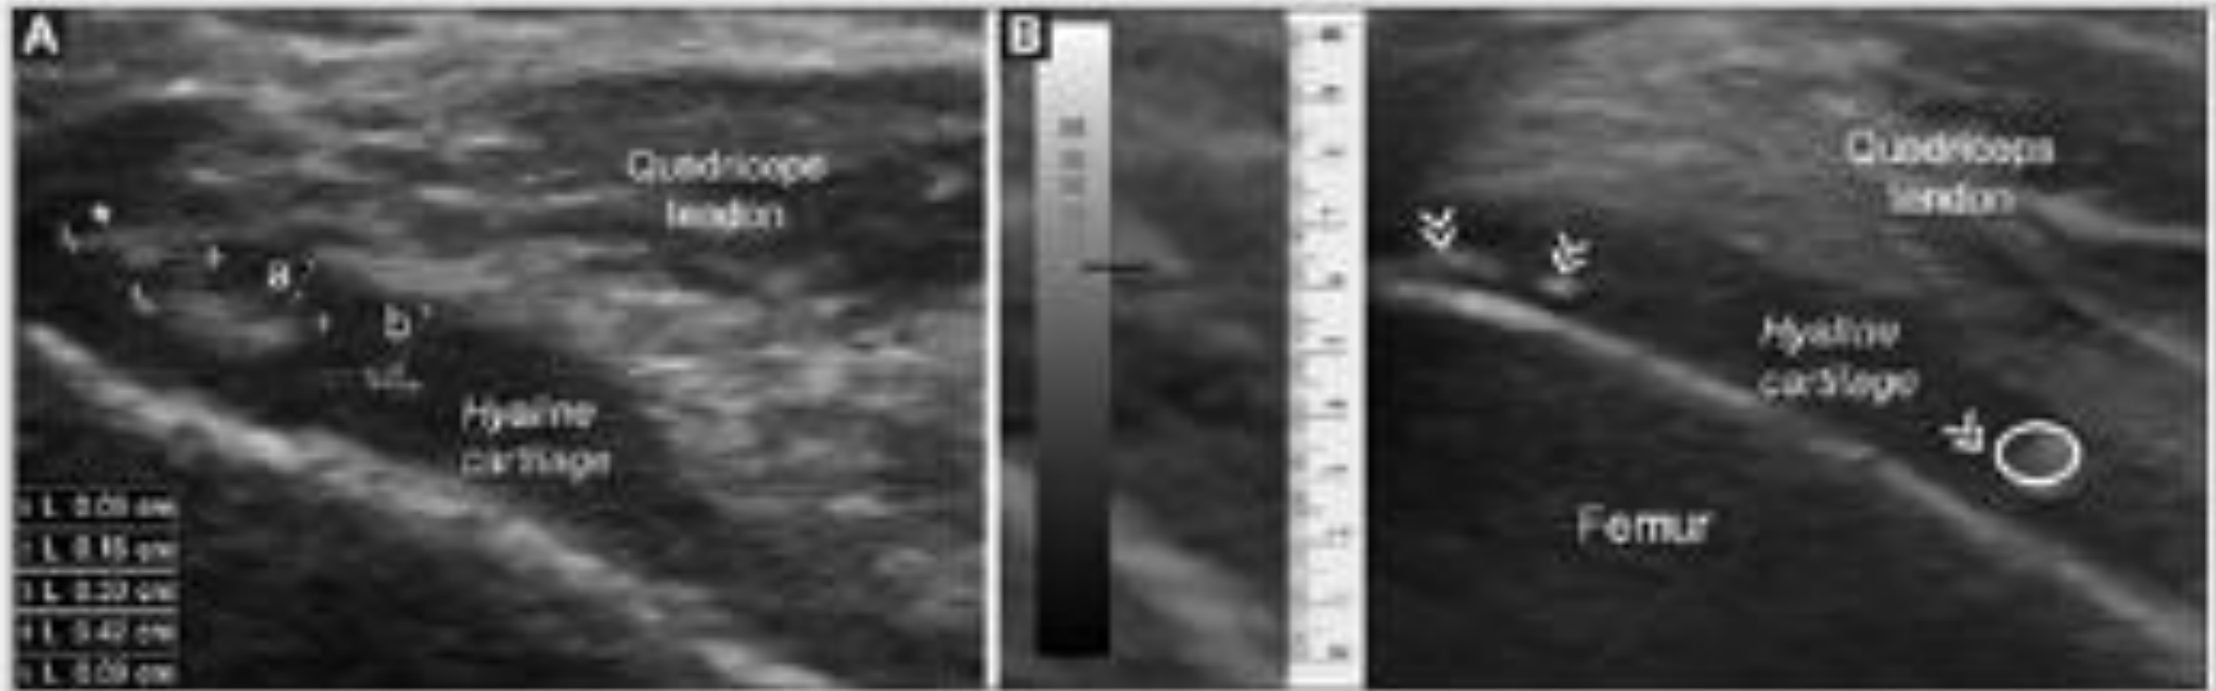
(A and B) Transverse sonographic views of the knee fully flexed. (A) The minimal-crystal distance ($a = 0.08$ and $b = 0.15$ cm) of two deposits of calcium. Notice the asterisk shows another small aggregate very close to the cartilage surface. (B) Several deposits of calcium (arrowheads) are showing. Also, a quantitative echogenicity assessment of a selected crystal aggregates (encircle area) using a scale of 0 to 10 cm is done
